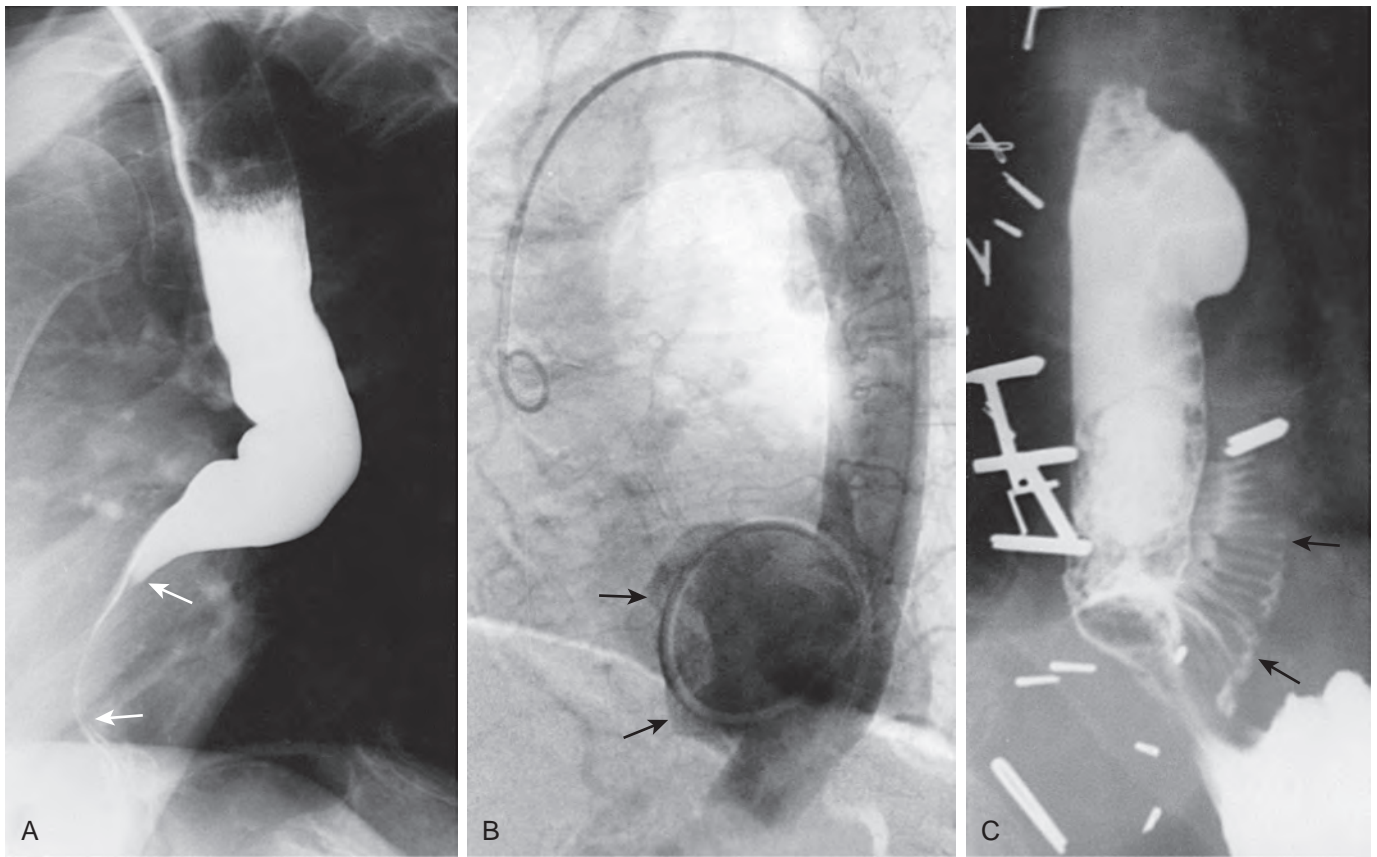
Aortoesophageal fistula caused by an aortic aneurysm. A. Initial esophagogram shows anterior displacement and narrowing of the distal esophagus (arrows) by an aneurysm of the descending thoracic aorta. B. Subsequent aortogram reveals a saccular aneurysm with intraluminal thrombus (arrows) occluding the origin of the fistula. Although radiographic studies failed to demonstrate the fistula, an aortoesophageal fistula was found at surgery. C. Another esophagogram after placement of a Dacron aortic graft shows a recurrent aortoesophageal fistula with extravasated contrast medium from the esophagus outlining the aortic graft (arrows). This fistula was caused by infection of the graft. (From Baron RL, Koehler RE, Gutierrez FR, et al: *Clinical and radiographic manifestations of aortoesophageal fistulas*. *Radiology* 141:599–605, 1981.)
